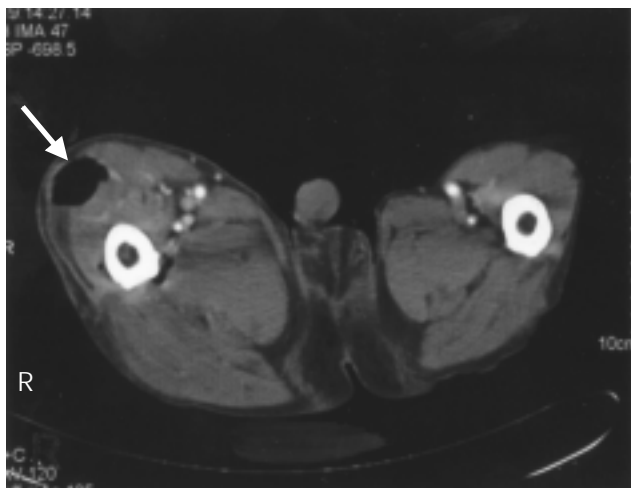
Computed tomographic image showing subcutaneous gas in the right thigh (arrow).
